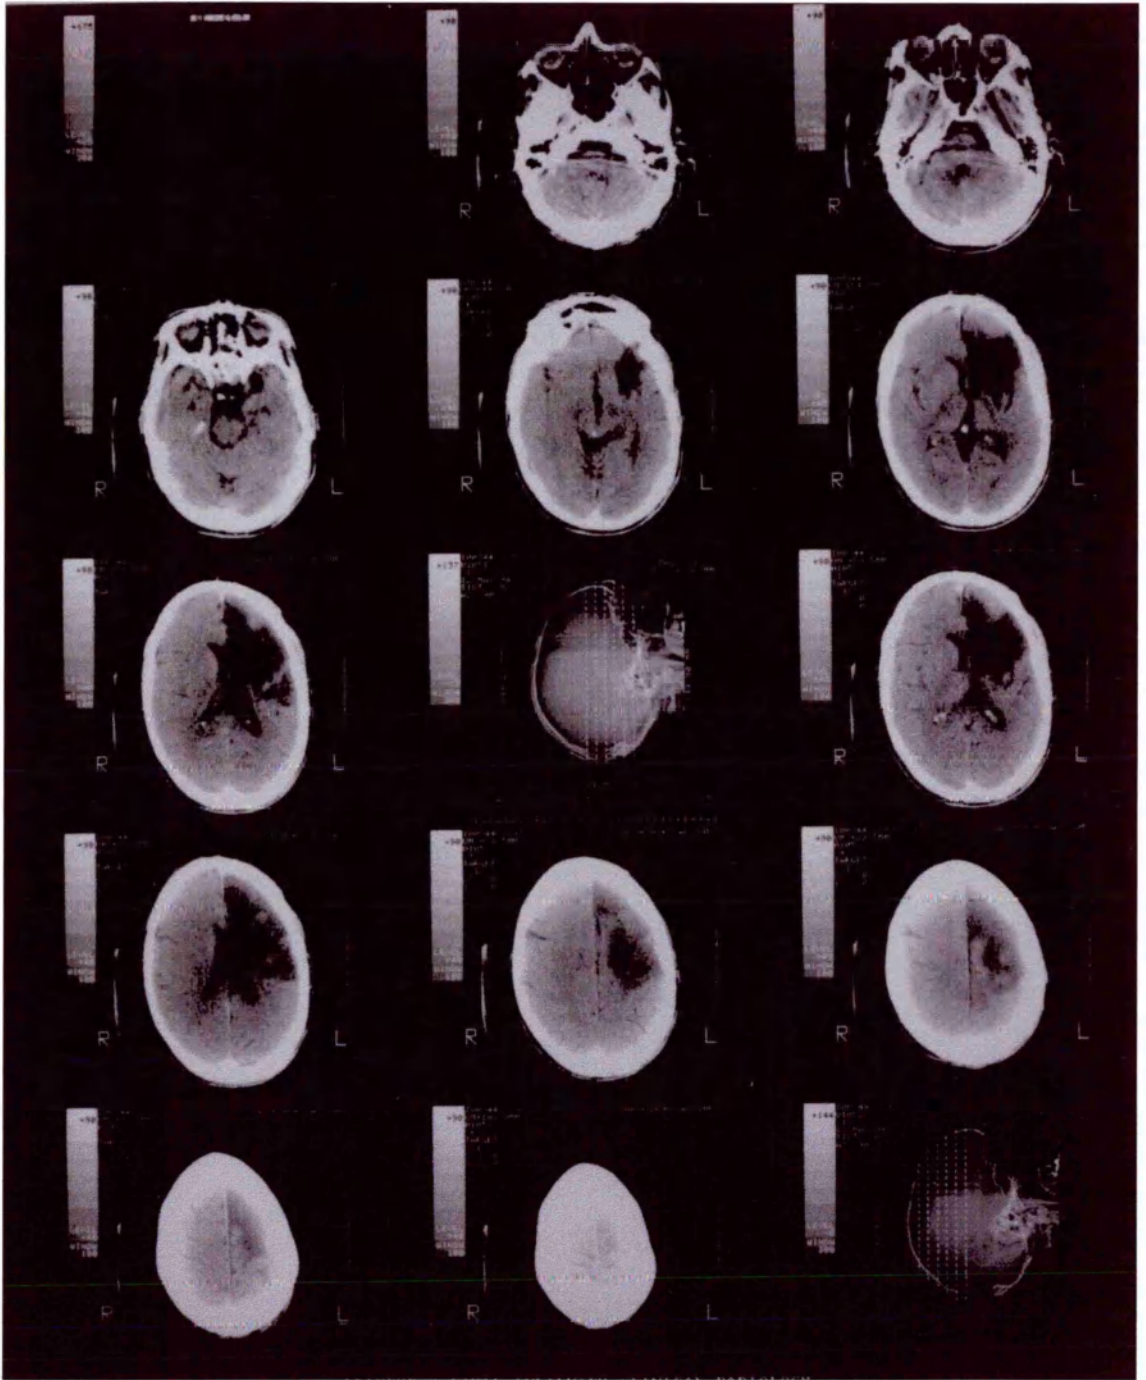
CT scan for JM.
